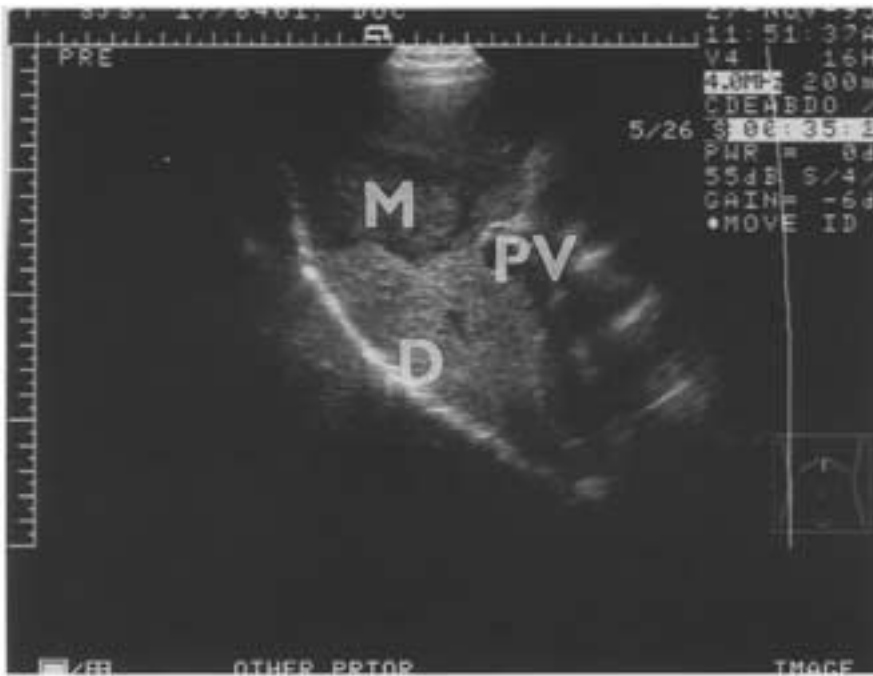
A typical pie-shaped field of view obtained by a sector plan ultrasound sweep. Here a large liver metastasis (M) from an oesophageal carcinoma is seen as a heterogeneous lesion of generally lower reflectivity than the surrounding liver. Conventionally the strength of echoes is represented by degrees of brightness in a grey scale image, the brighter the image the stronger the reflection. This is a longitudinal section through the liver as depicted by the plane of section (small vertical line) in the body icon in the bottom right. D, diaphragm; PV, portal vein. (Kindly supplied by Dr David Cosgrove, Department of Diagnostic Radiology, Hammersmith Hospital.)
